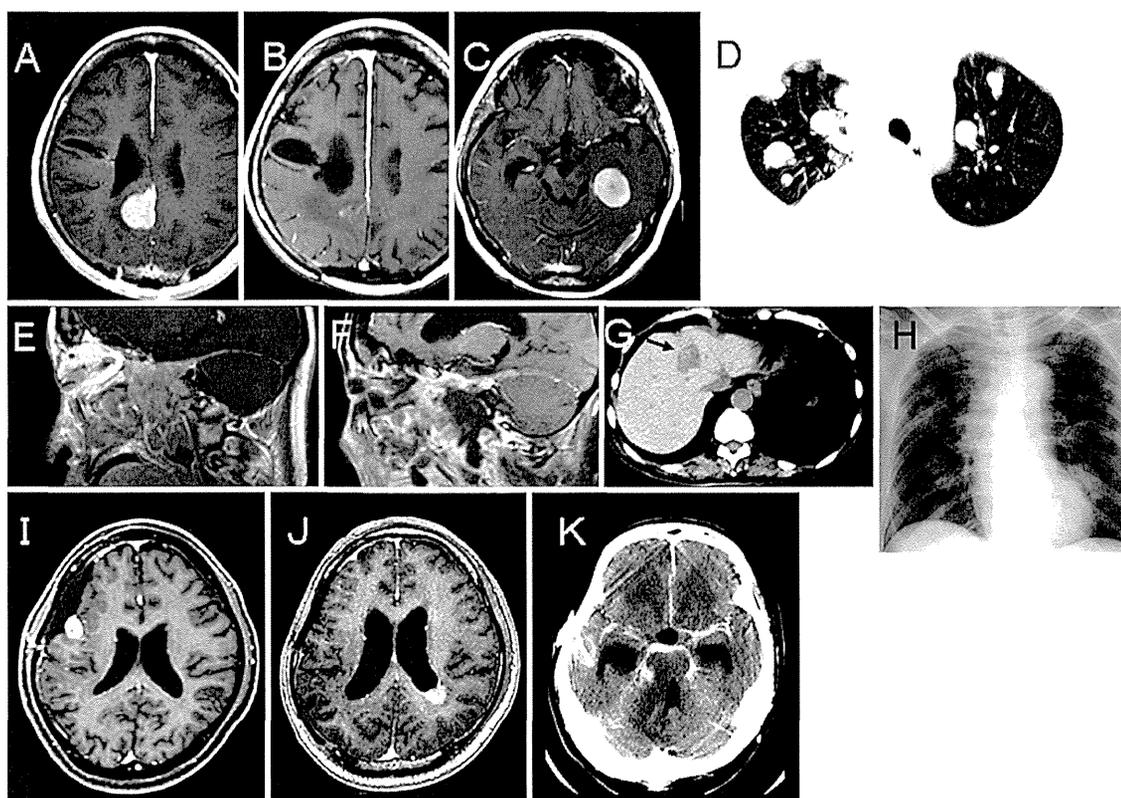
Typical images of systemic metastasis, intracranial recurrence outside the field of neutron irradiation, and CSF dissemination. A–D: Case 13 (anaplastic meningioma). Axial contrast-enhanced MR images obtained prior to BNCT (A) and 33 months after BNCT (B and C), and plain chest CT scan obtained 39 months after BNCT (D). The MRI (C) shows intracranial recurrence out of the field of neutron irradiation. The chest CT scan (D) shows lung metastasis of the meningioma. This patient died due to dyspnea. The patient had already suffered from metastasis of the meningioma at the left clavicle prior to BNCT. E–H: Case 7 (sarcoma transformed from anaplastic meningioma). Sagittal contrast-enhanced MR image obtained prior to BNCT (E); sagittal contrast-enhanced MR image (F), plain abdominal axial CT scan (G), and chest radiograph (H) obtained 7 months after BNCT. The original, very large tumor was well controlled by BNCT, but lung and liver metastasis occurred. This patient died due to dyspnea. The black arrow (G) shows liver metastasis. I–K: Case 11 (anaplastic meningioma). Axial contrast-enhanced MR images obtained prior to BNCT (I) and 7 months after BNCT (J); axial contrast-enhanced CT scan (K) obtained 10 months after BNCT. The original tumor was controlled well, but CSF dissemination with untreatable hydrocephalus occurred.
